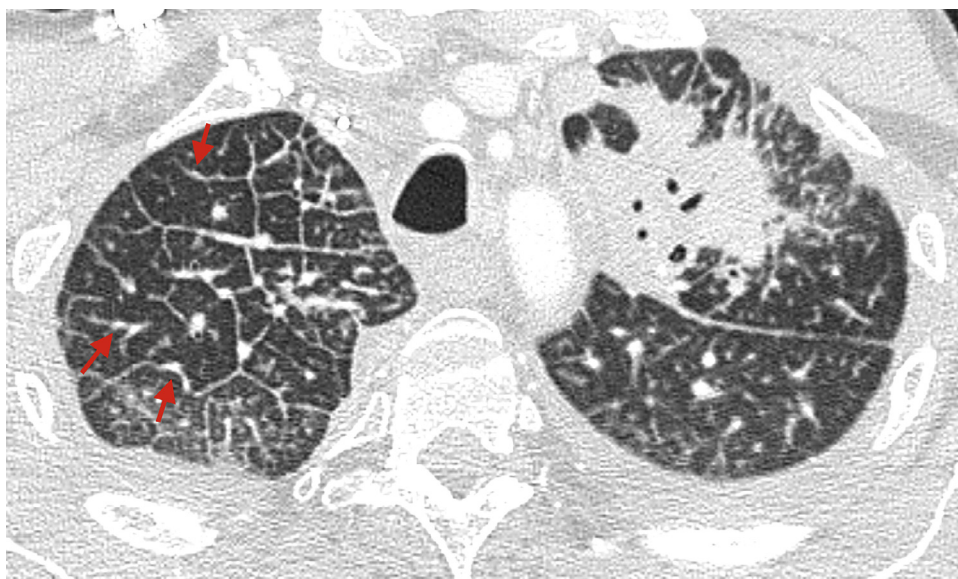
Contrast enhanced computed tomography scan of the chest shows a left upper lobe mass, bilateral pleural effusions, along with thickened, somewhat nodular interlobular septa.
